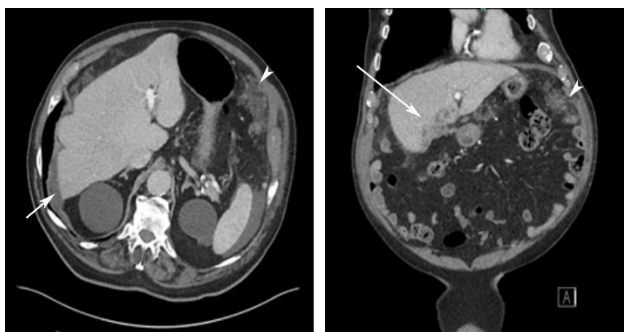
Axial and coronal views of a CT scan 5 months post-operatively showing direct liver invasion (long arrow), malignant ascites (short arrow) and omental caking (arrowhead) consistent with disseminated peritoneal disease.
